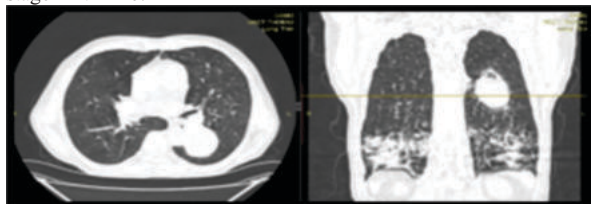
Axial And Coronal Section Of HRCT Thorax In Lung Window
